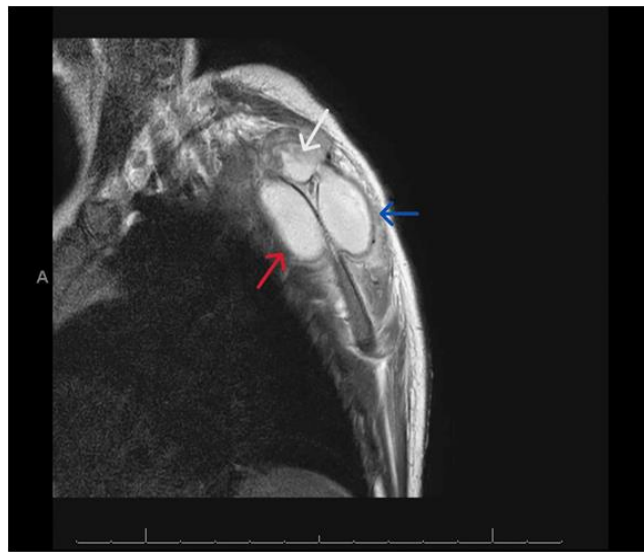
Left-shoulder MRI T2 Sagittal cut with contrast revealed three fluid loculations in the subscapularis (red arrow), supraspinatus (white arrow), and infraspinatus (blue arrow) muscles.
